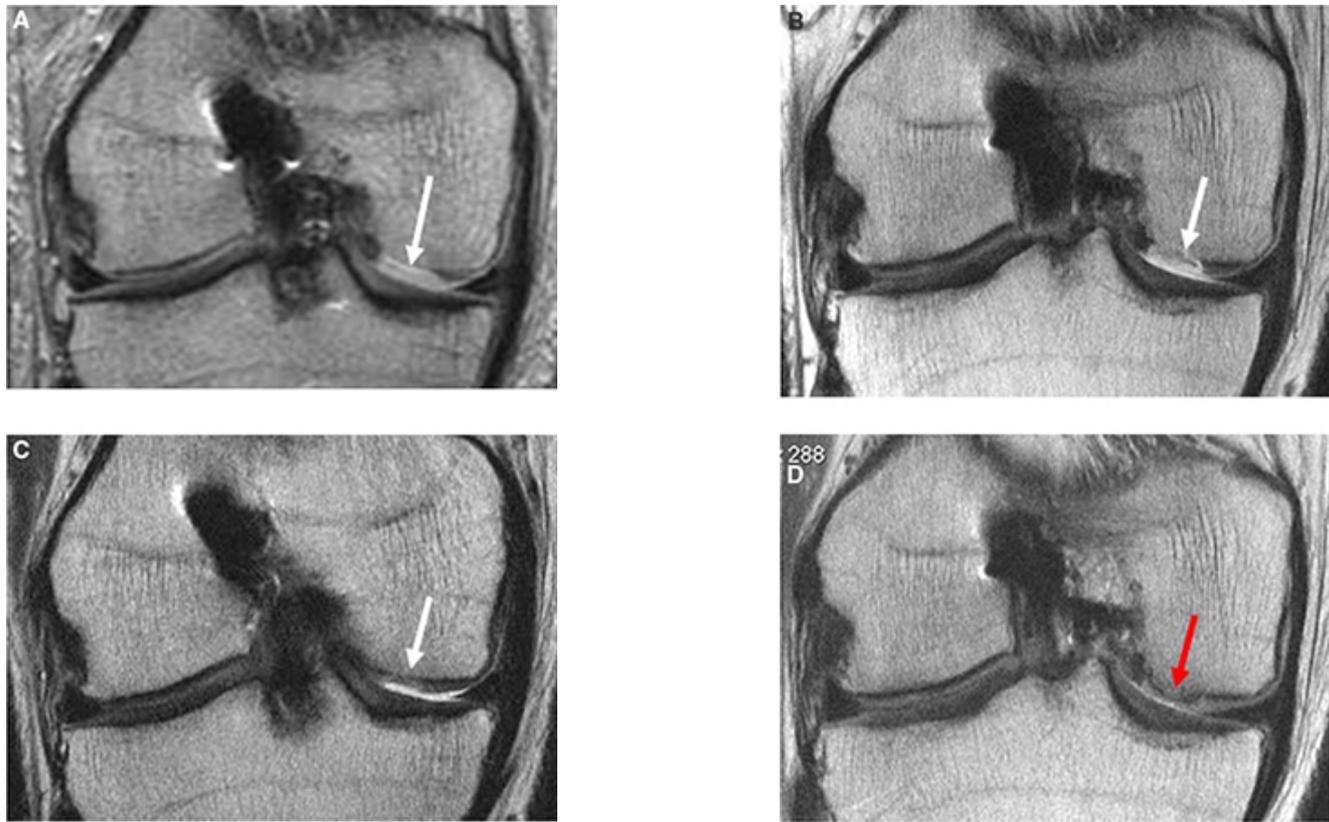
Coronal magnetic resonance images after implantation of the NeoCart patch over the medial femoral condyle demonstrate good fill of the cartilage defect as well as progressive decreased signal intensity of the repair tissue, approaching that of adjacent native cartilage (white arrows). A, Ten days after NeoCart implantation. B, One month after NeoCart implantation. C, Three months after NeoCart implantation. D, Eleven months after NeoCart implantation. Development of focal underlying subchondral bony remodeling is noted (arrow).
